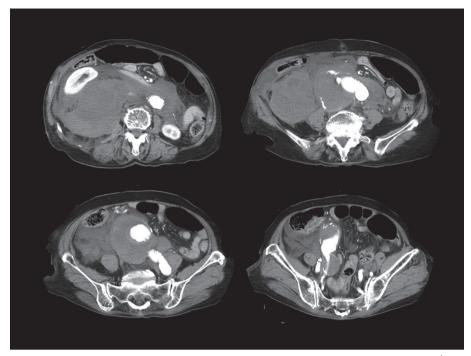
Preoperative contrasted computed tomographic images showing a rupture of the right common iliac artery aneurysm (B) with a massive right retroperitoneal hematoma (A), bilateral common iliac artery aneurysms (C) and a right internal iliac artery aneurysm (D).
